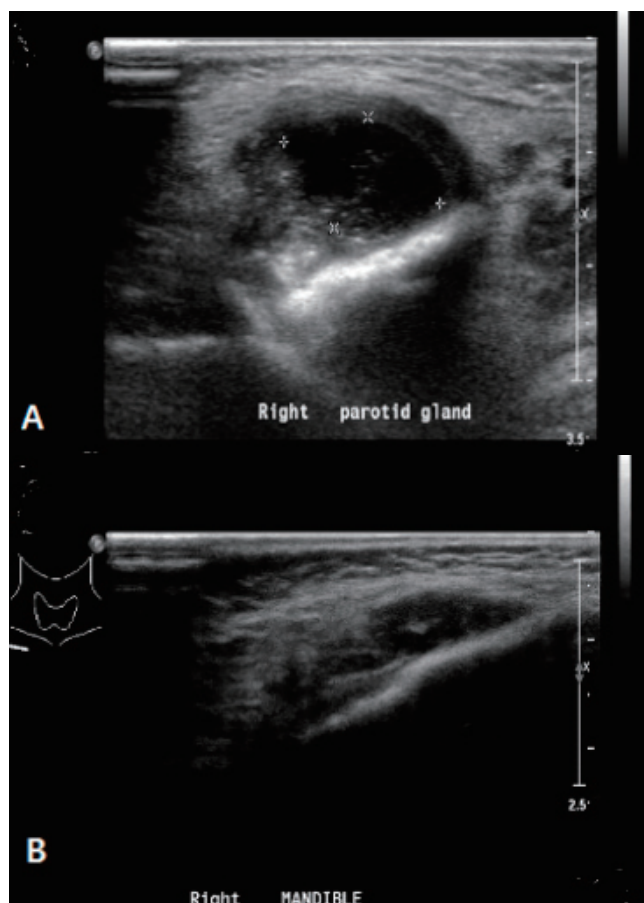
Ultrasonography of face and neck. (A) At the 5th hospital day, early abscess formation was seen in the right masticator space. (B) The previously seen masseter muscle swelling was decreased at about 1 month after discharge.
